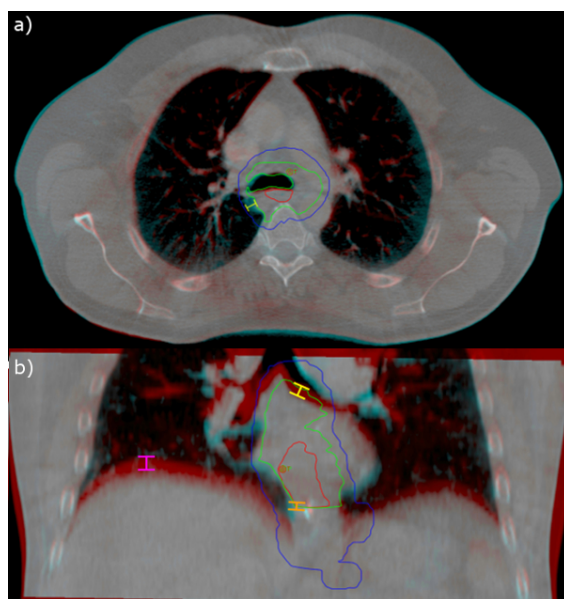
Red outline: Gross tumour volume (GTV); Blue outline: PTV; Green outline: target surrogate structure (SS). Red image: CT; Turquoise image: CBCT. a) Fraction 15 of 23 of RT (25,2Gy delivered in 1,8Gy fractions). Tissue surrounding the GTV has swollen by 6,7mm (yellow marker). This anatomical change is registered as a SS tolerance violation. b) Fraction 16 of 23 of RT (27,0Gy delivered in 1,8Gy fractions). The diaphragm baseline has shifted 8,7mm in caudal direction (magenta marker), stretching the mediastinum 7,9mm in the same direction (yellow marker) and displacing a gold implant near the target base by 5,1mm caudally (orange marker).
